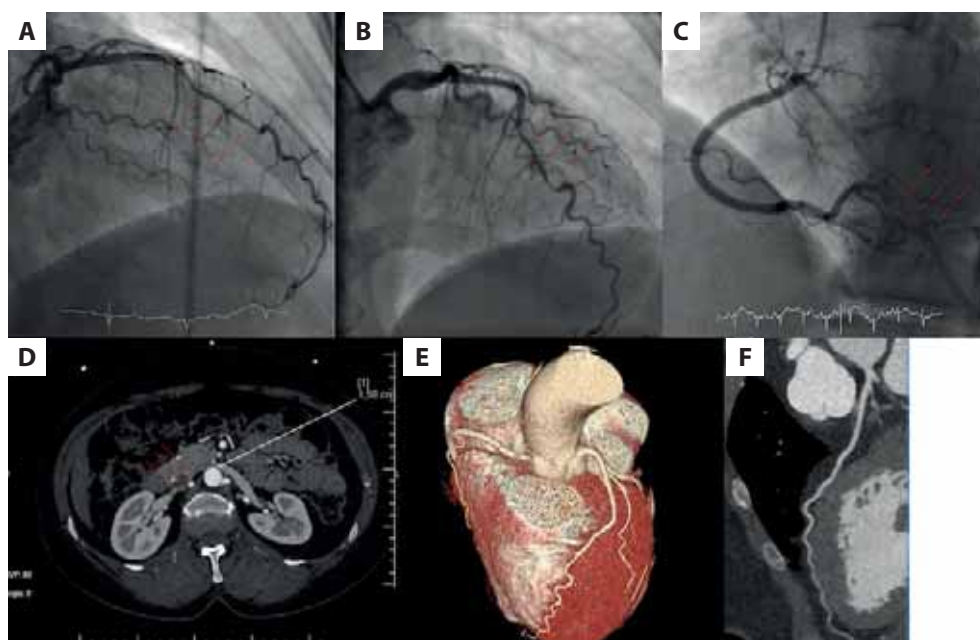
A–B. Coronary angiography showing spontaneous coronary artery dissection (SCAD) of the left anterior descending artery. C. Coronary angiography showing SCAD of the posterolateral branch from the right coronary artery. D. Computed tomography (CT) showing the right renal artery with morphology characteristic of fibro-muscular dysplasia. E–F. CT showing complete healing of coronary arteries
